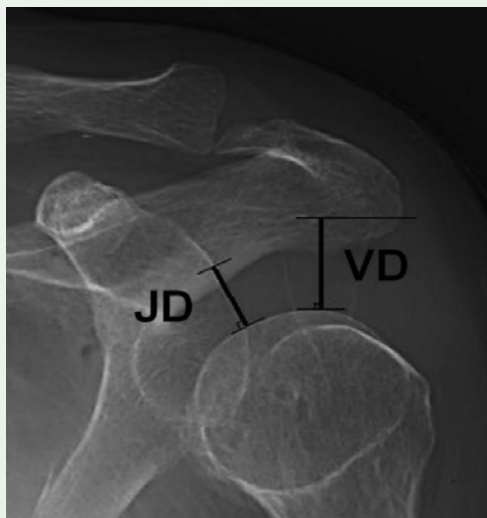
Shoulder anterior-posterior simple radiograph in a sitting position. Vertical Distance (VD) is the distance between the most inferior and lateral level of acromion and the uppermost level of humeral head. Joint Distance (JD) is the shortest distance between upper glenoid rim and humeral head.
